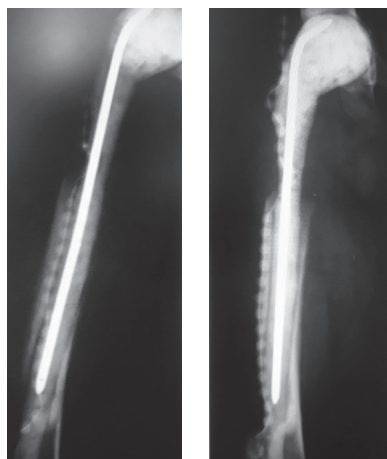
X-ray of the right thigh. Extensive defect of the cortical bone at the border of the middle and distal thirds of the femur
